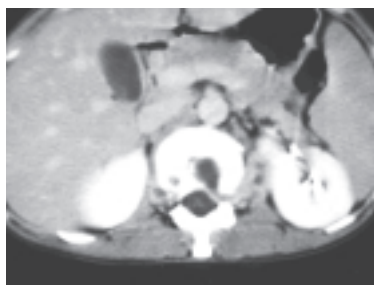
Enhanced axial CT scan taken at the level of L1 vertebra.
